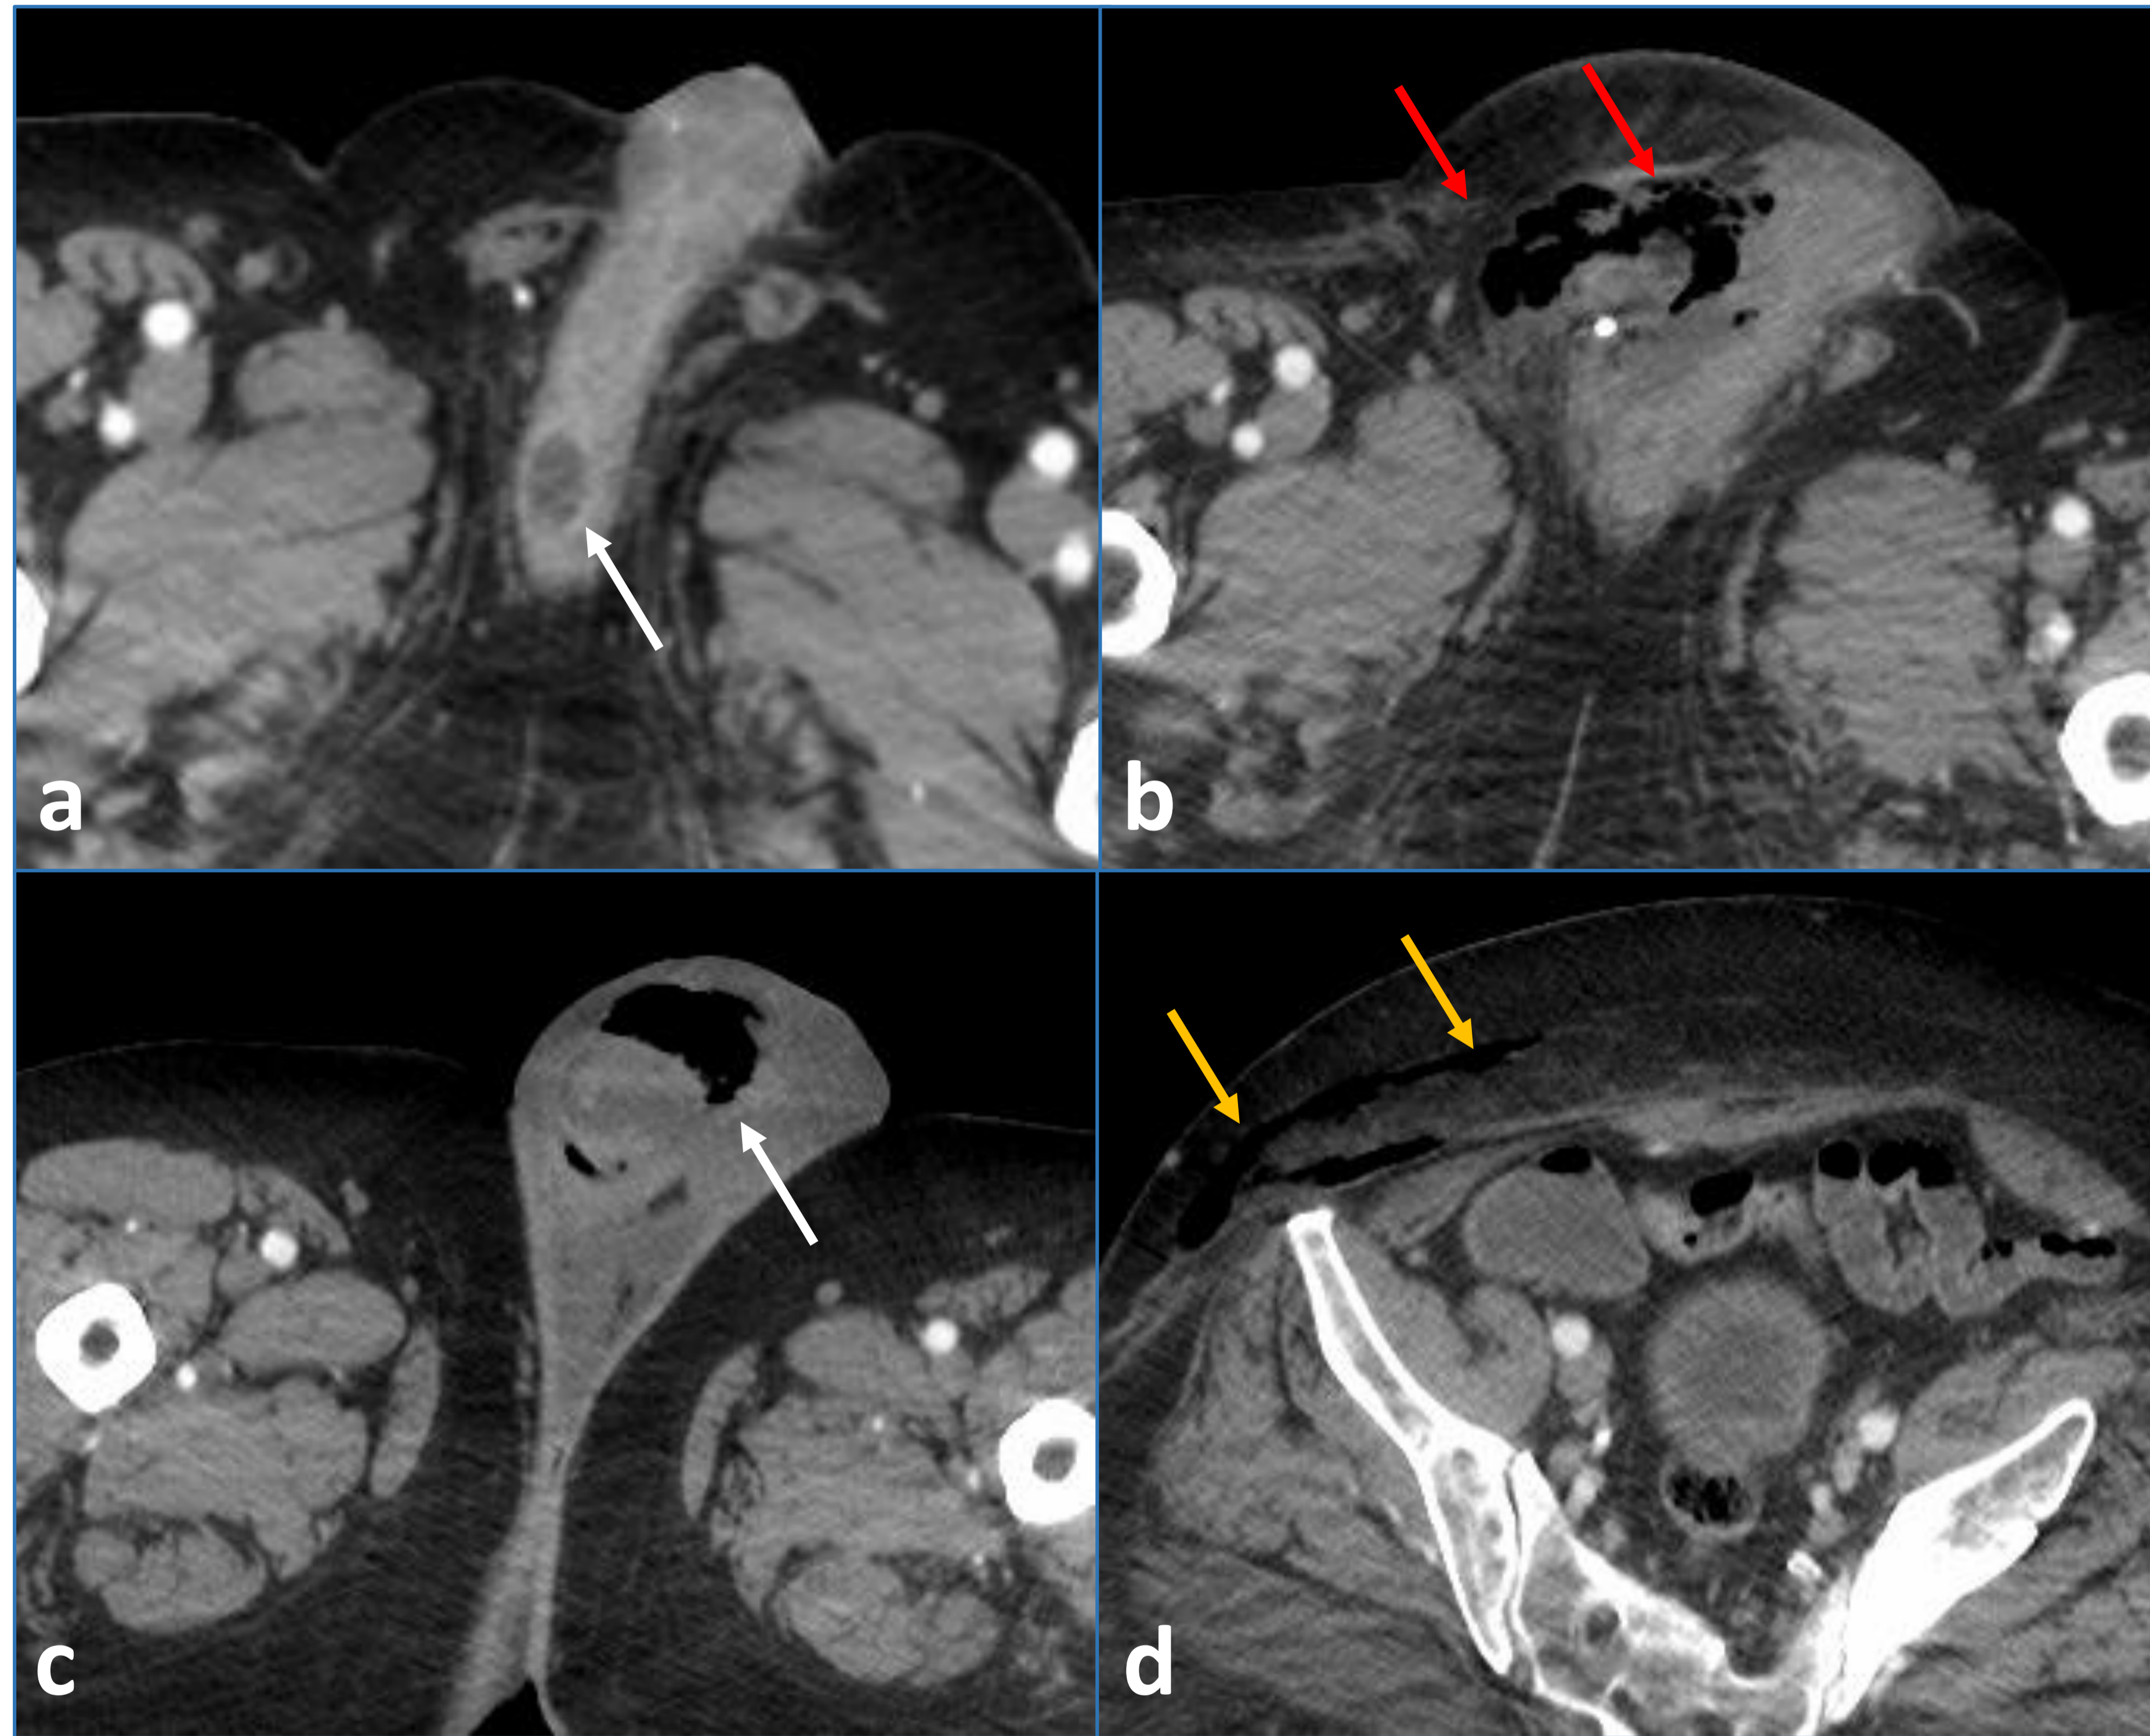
Fournier's gangrene with penoscrotal abscess. a axial CT image shows a small abscess at penoscrotal junction (arrow). b axial CT image of same patient obtained 3 months later shows progression into Fournier's gangrene (red arrow). c, d axial CT images at different section show bilateral scrotal edema with soft tissue gas along right hemiscrotum (arrow) and along abdominal wall (yellow arrow).
